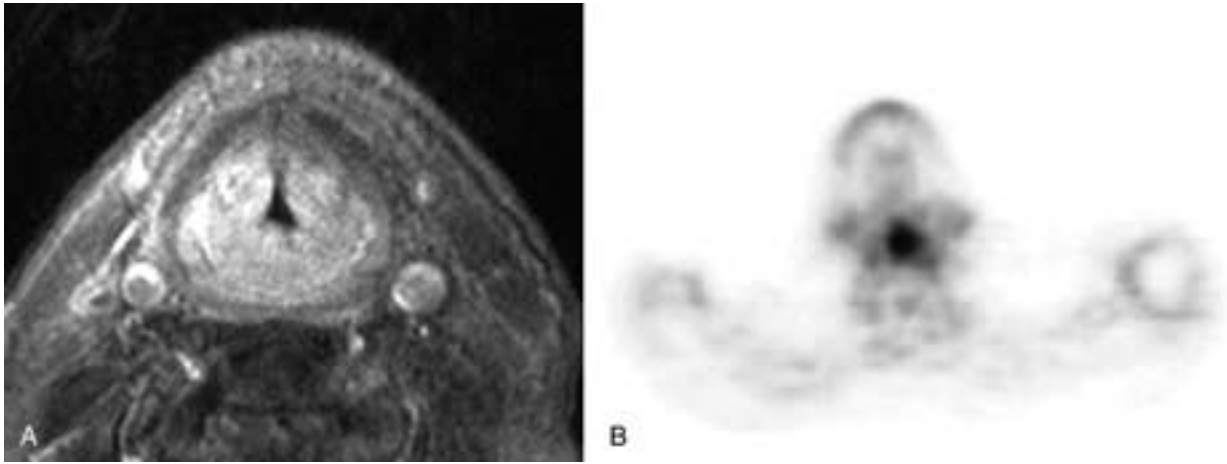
A 63-year-old man underwent radiation therapy for SCC of the larynx. Six months following completion of therapy, he had persistent severe pain and occasional hemoptysis. Endoscopic examination demonstrated marked diffuse mucosal edema and erythema. A, An axial T1-weighted, postgadolinium, fat-saturated MR image demonstrates marked laryngeal edema and moderate enhancement without a focal abnormality. B, The FDG PET scan demonstrates a focus of intense activity in the larynx and no evidence of pathologic nodes. Mild diffuse soft-tissue activity is due to prior radiation therapy. Because of persistent symptoms and the suspicious PET scan, a laryngectomy was performed. SCC was demonstrated at pathologic examination.
